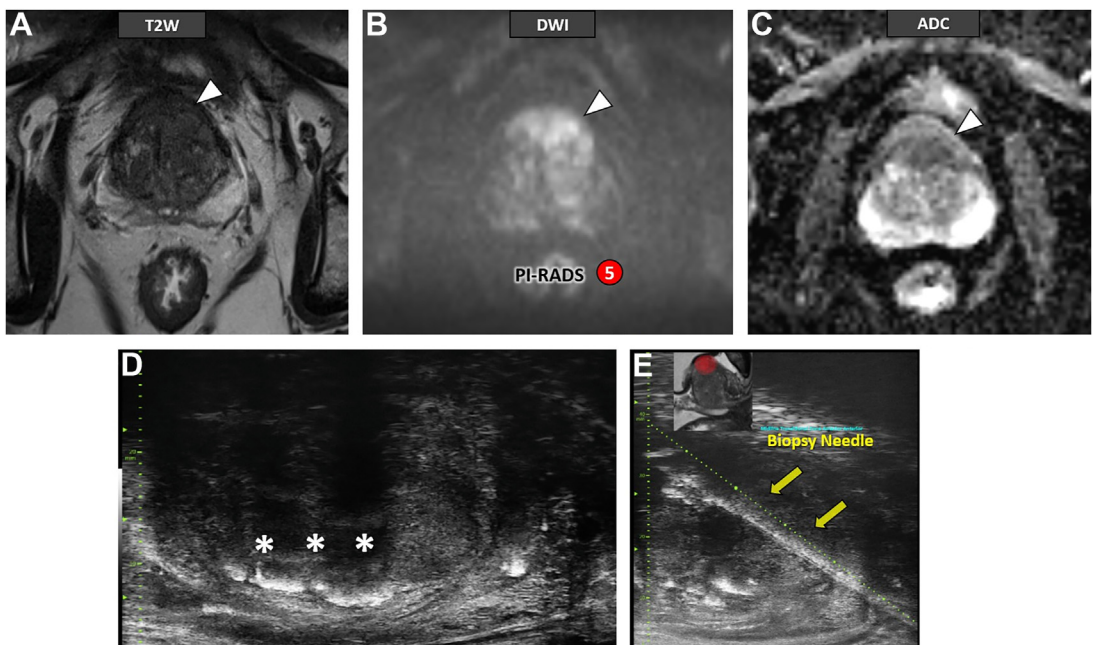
Images in a 71-year-old man with prostate-specific antigen level of 12.3 ng/mL. Multiparametric MRI scans (T2-weighted [A], diffusion-weighted imaging [B] and ADC map [C]) show a 2-cm PI-RADS 5 lesion (*arrowheads*) in the anterior transition zone. (C) MicroUS scan (D) failed to detect the site of the tumor, due to shadowing from calcification in corpora amylacea (*asterisks*), limiting the assessment of anterior gland. Targeted MicroUS/MRI fusion (FusionVu) (E) biopsies (using software platforms to integrate the MRI and ultrasound data) revealed grade group 2 disease. PI-RADS, Prostate Imaging Reporting and Data System.
